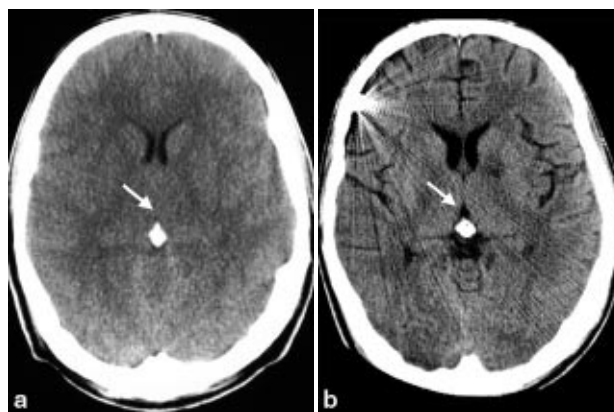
a Cranial computed tomography scan at level of epiphysis showing sulcal effacement, diffuse white-matter hypodensity, bilateral compression of frontal horns and lacking visibility of third ventricle (arrow) indicating extensive cortical and subcortical cerebral oedema. b Cranial computed tomography scan at identical level obtained 4 days after initial examination showing restoration of grey-white differentiation and normal width of sulci and ventricles. Note small hypodensities of left internal capsule and occipital cortex due to ischaemic infarcts and metallic artefact of epidural transducer in the right frontal region
